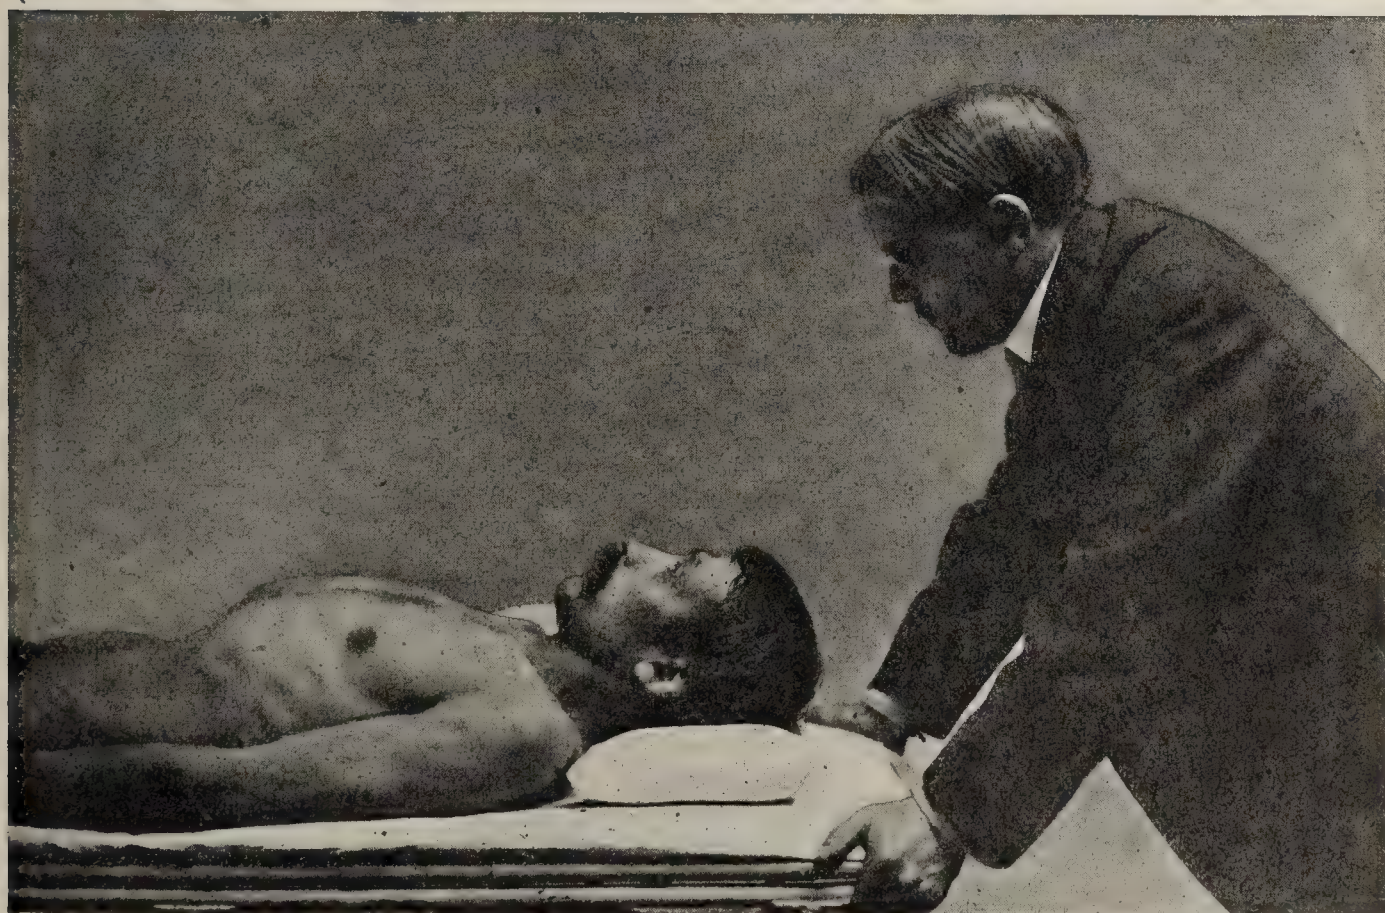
INSPECTION OF THE CHEST AND ABDOMEN.
